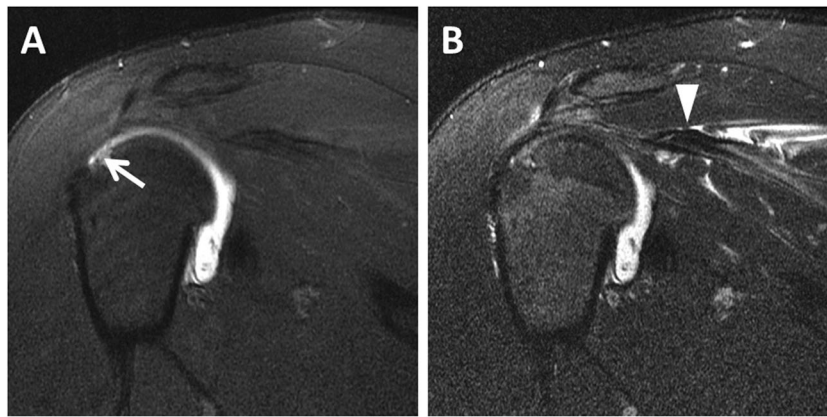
A 27-year-old male with a lifting injury 1 day earlier presenting with pain and decreased external rotation strength. (a) Coronal T1-weighted fat-suppressed image after arthrography fails to show any communication of contrast from the glenohumeral joint to the overlying subacromial-subdeltoid bursa. The infraspinatus tendon footprint was intact on MR arthrography (*arrow*) as well as on arthroscopy. (b) However, a corresponding coronal fluid-sensitive image shows edema
